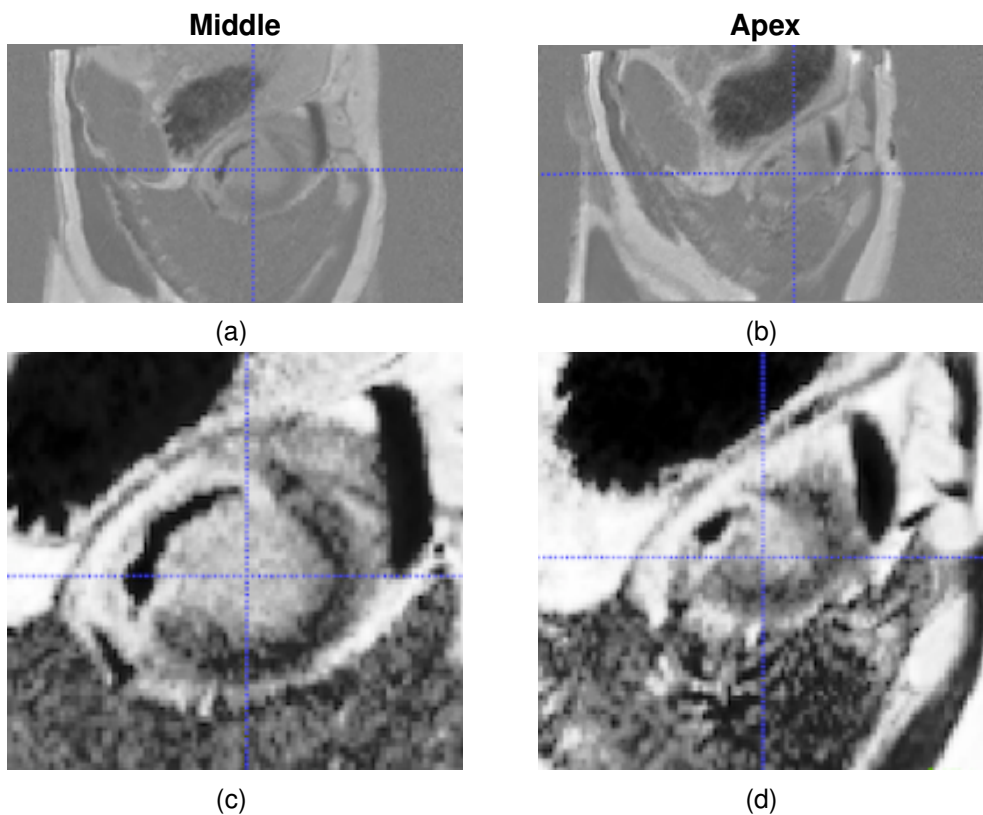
Two LGE-MRI slices of a patient, showing the original image (a, b) and the preprocessed image (c, d).
